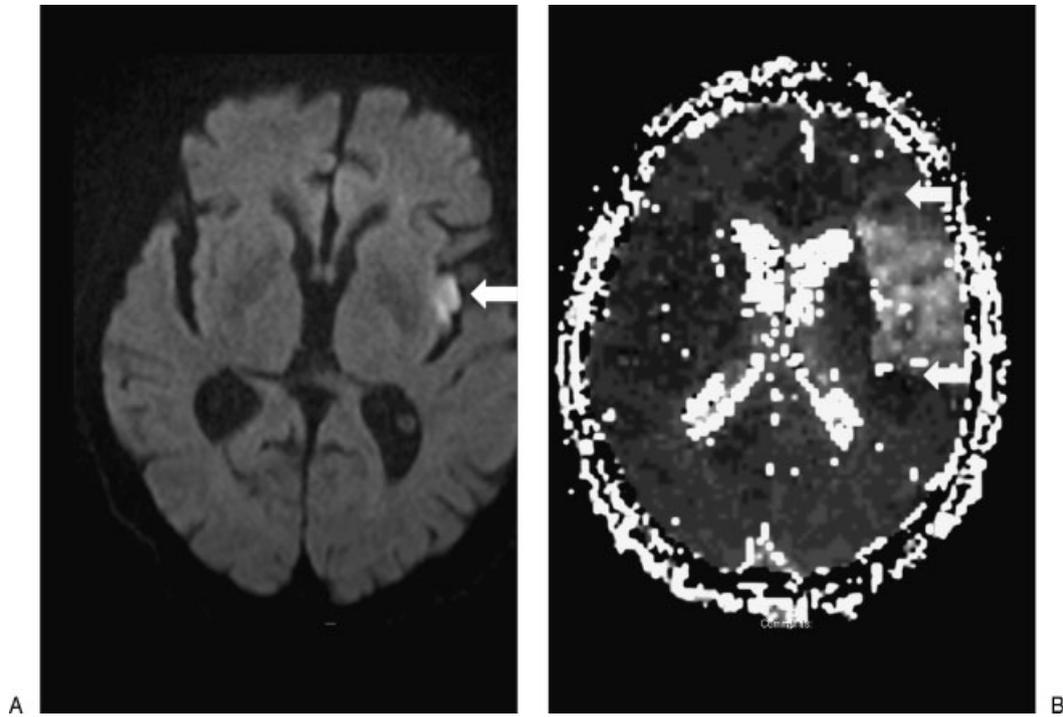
(A) A diffusion-weighted image MRI (DWI) scan shows a small stroke in the left insula (arrow). (B) A perfusion weighted MRI (PWI) scan reveals that the stroke involves a much larger area as shown by arrows. This patient presented with right-sided weakness and aphasia better described by the lesion on PWI seen here than on DWI. This likely represents the ischemic penumbra or brain area at risk.
